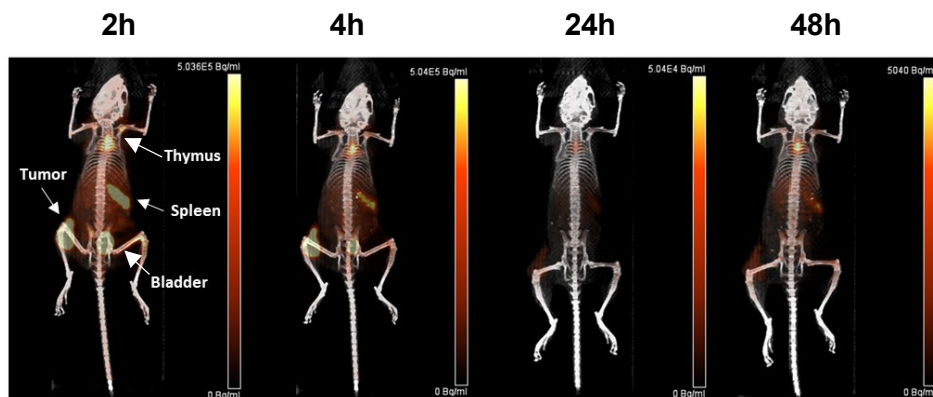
Representative timecourse of ^{64}Cu -LLP2A in BPR α tumor model. Shown are PET/CT maximum-intensity projections.
